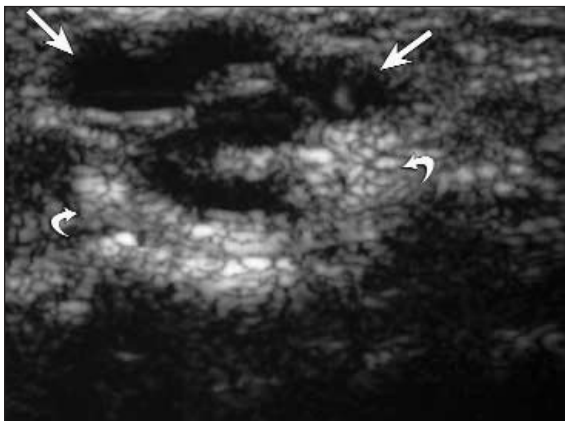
Volar ganglion cyst in a 36-year-old man. Sagittal sonography shows a 14-mm anechoic ganglion cyst (arrow) with posterior acoustic enhancement (curved arrows). Note the well-defined border and displacement of the radial artery.
